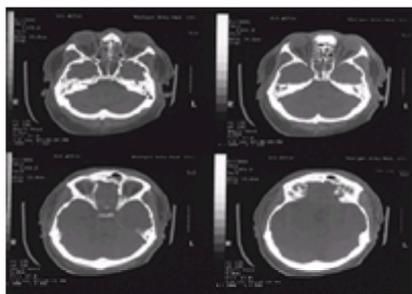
Noncontrast cranial computed tomography of the patient with freshwater drowning. Note obliteration of the subarachnoid space and ventricles consistent with diffuse cerebral edema. Note also frontal and ethmoid sinus fluid density and air–fluid levels.
